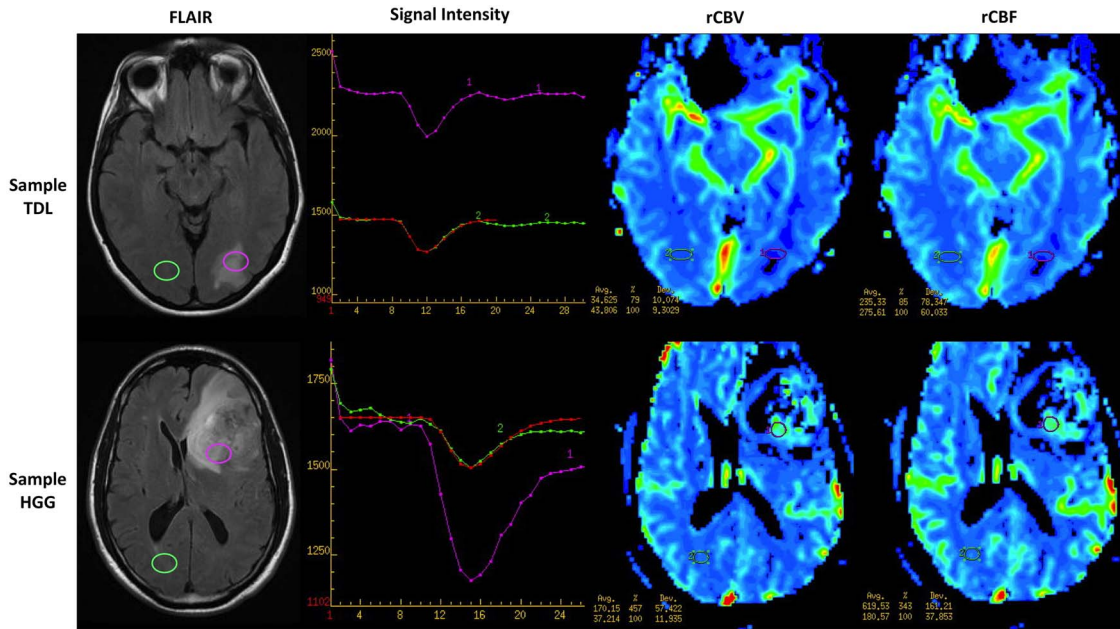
Perfusion MRI rCBV and rCBF were calculated as a ratio of lesion (purple) to contralateral normal appearing white matter (green).
